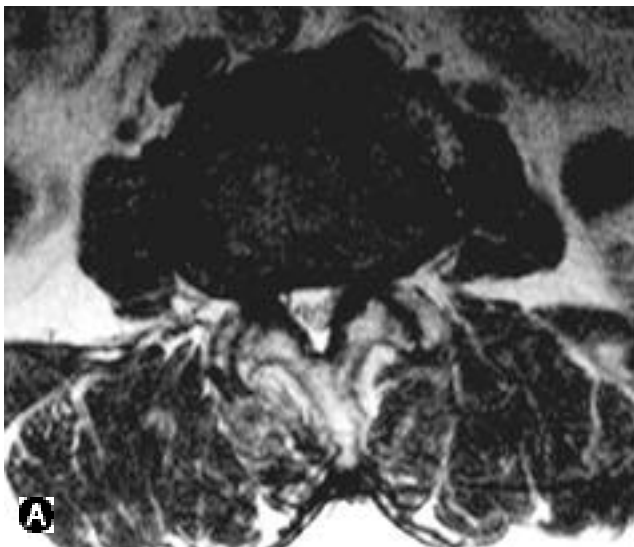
Preoperative MRI image (A) and postoperative CT image (B) of spinous process osteotomy patient.
